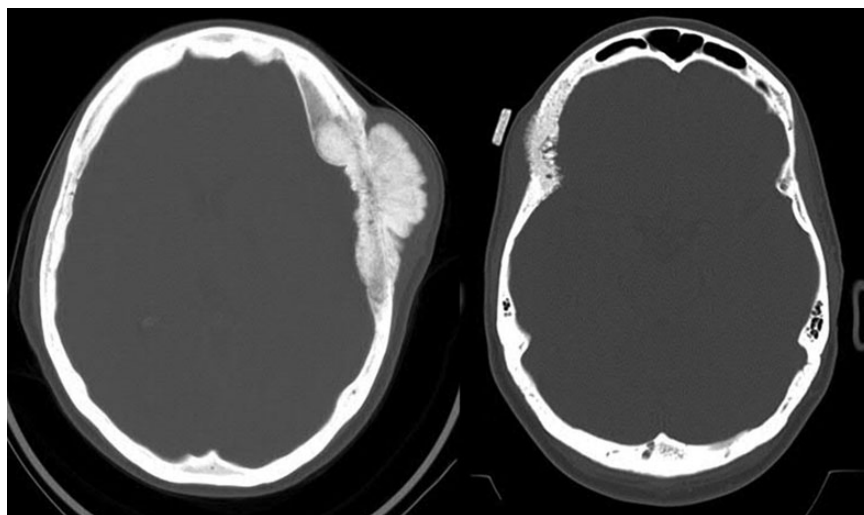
CT appearance of cranial hyperostosis in 2 different patients with bone invasion of meningioma.
